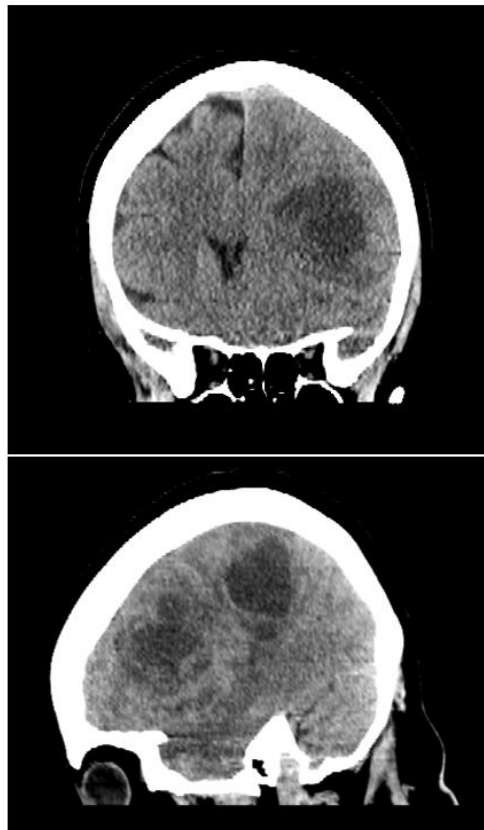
CT Brain without contrast showing large left cerebral hemispheric masses with vasogenic edema and midline shift.
